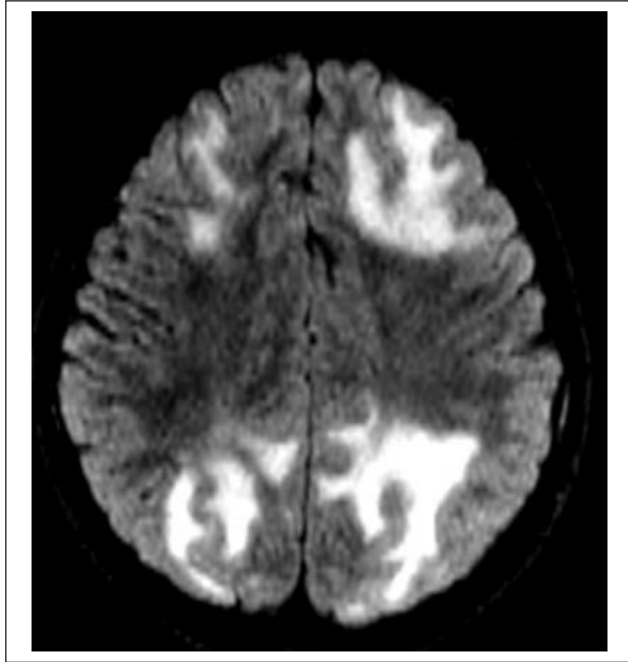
Axial FLAIR images show abnormal hyperintense signal in the bilateral parietal and left frontal region.
